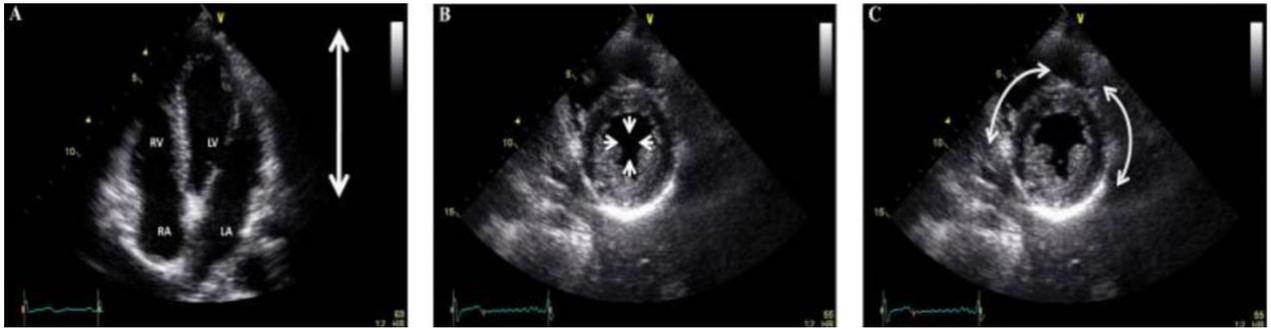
Apical four chamber view demonstrating where longitudinal deformation would occur (left), a short axis view at the papillary muscle level showing radial displacement towards the centre (middle), and a short axis view demonstrating circumferential deformation at the papillary muscle level (right) (Lopez-Candales and Hernandez-Suarez, 2017).*
